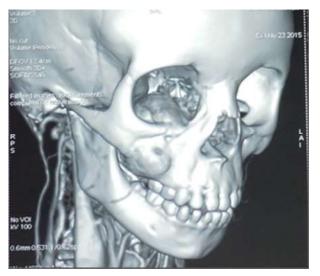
3D CT reconstruction showing moderately large nearly spherical mass totally replacing the right maxillary antrum.
